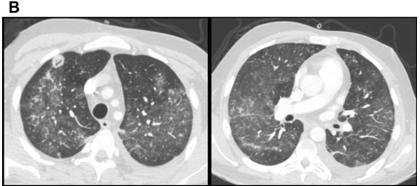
Radiographic findings of diffuse alveolar hemorrhage. (*A*) Chest radiograph shows bilateral patchy infiltrate. (*B*) Computed tomography images show bilateral ground-glass infiltrates with associated necrotizing nodule in right upper lobe.
